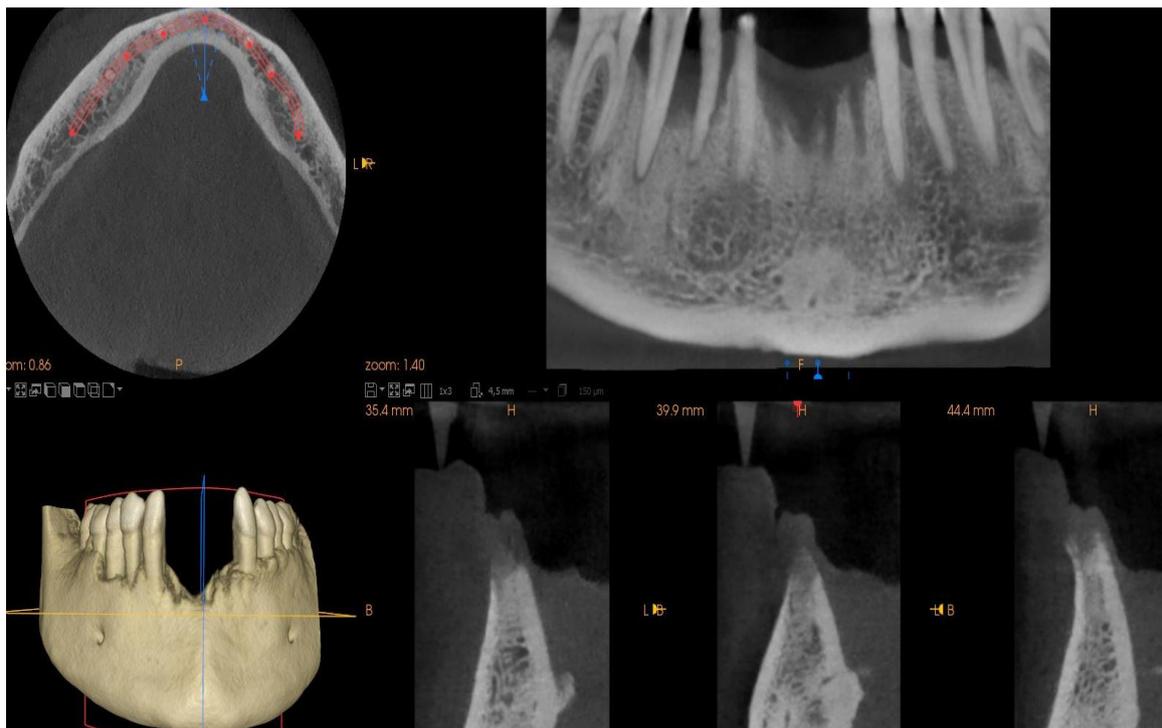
Cone beam CT image of lower jaw in preparation for surgery
